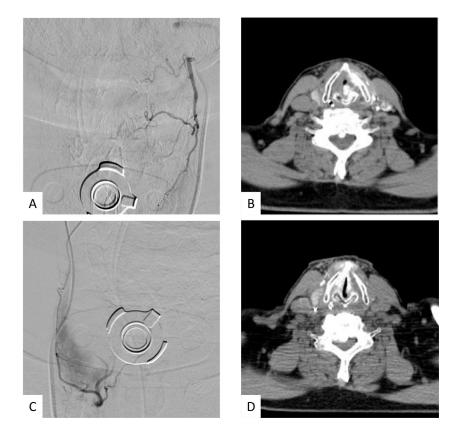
Angiography and IVR-CT images of a 69-year-old male with T3N0M0 stage III left glottic cancer (case 3). (A) Frontal angiography of the left superior thyroid artery (STA), including the superior laryngeal artery (SLA) branch; (B) image of the left STA using a sliding computed tomography scanner system with interventional radiology features (IVR-CT). Part of the left glottis shows an unenhanced area; (C) frontal angiography of the right STA, including the SLA branch; (D) IVR-CT image of the right STA. Part of the left glottis shows an enhanced area.
